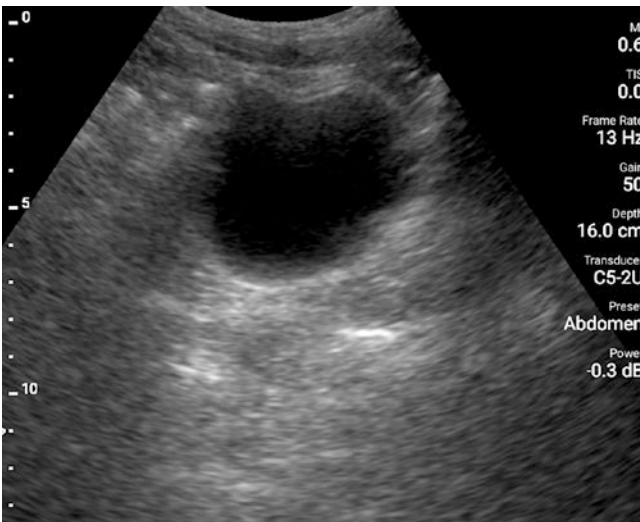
Ultrasound image of bladder distention in the longitudinal plane. The dimensions of the anechoic fluid-filled bladder can be measured in order to calculate volume. See Video 28.6. (Image courtesy of Stephen Alerhand.)
